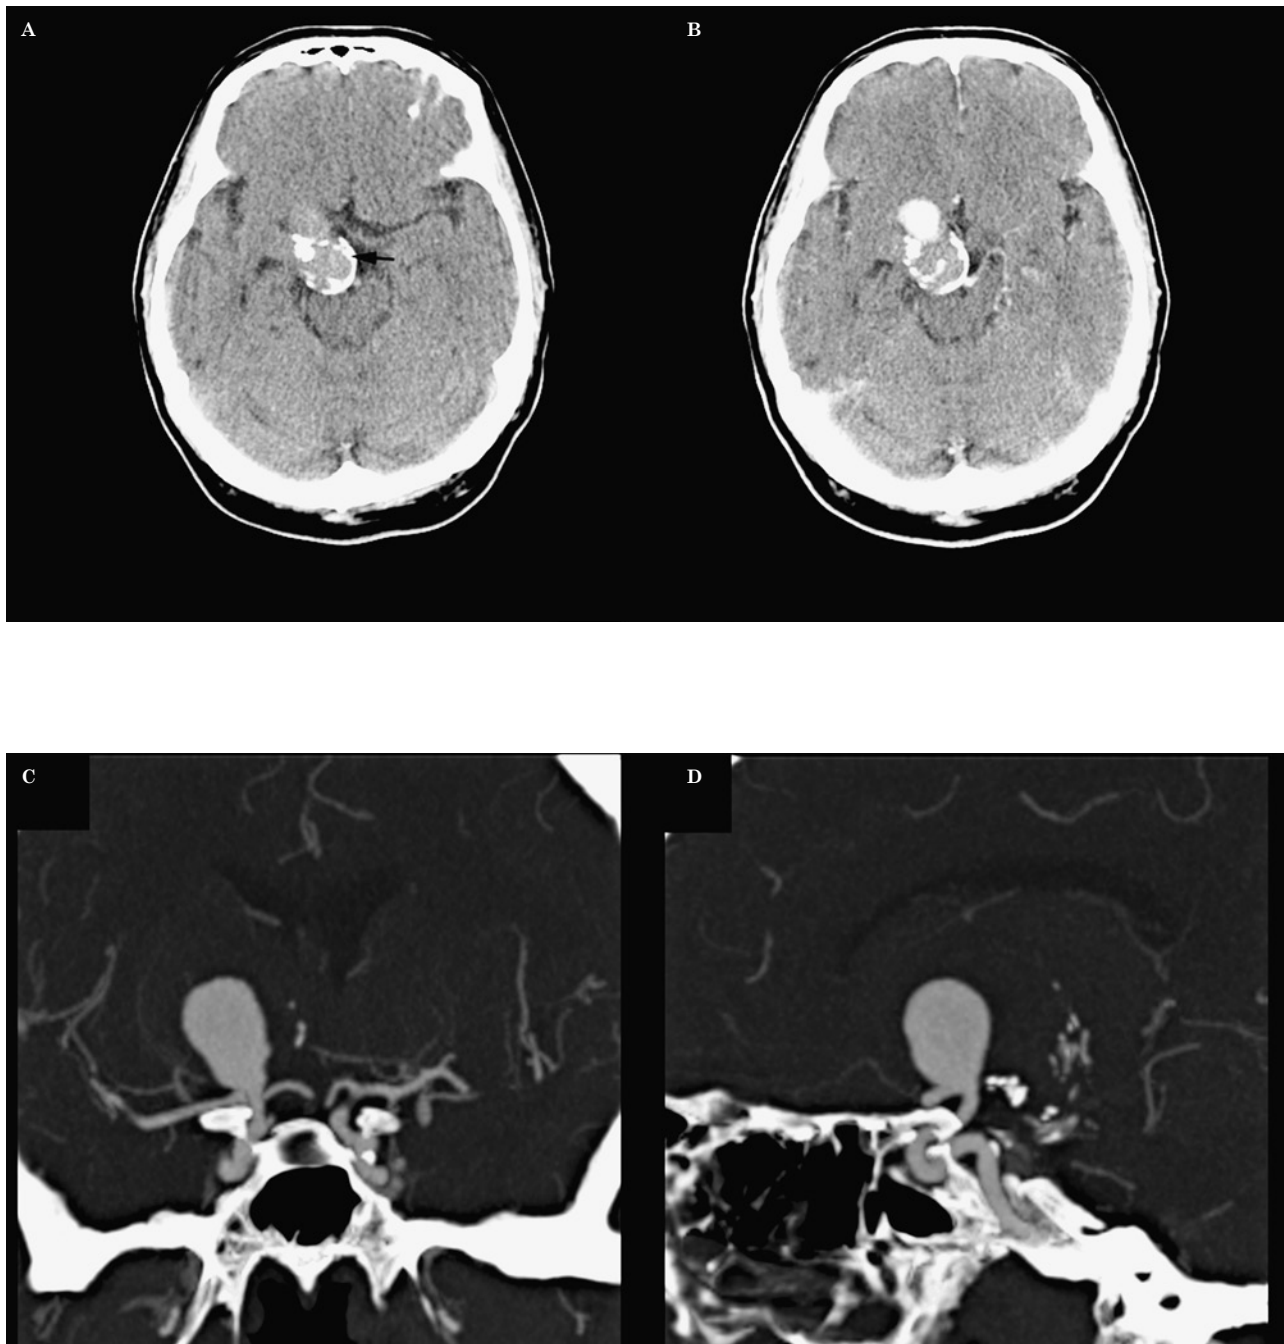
Aneurysm. A) Extensive curvilinear calcifications (arrow) are seen on a precontrast CT image in a patient with a saccular right middle cerebral artery aneurysm. Contrast is noted filling the aneurysm on the axial post contrast (B) and the coronal (C) and sagittal (D) maximum intensity projection (MIP) images.
